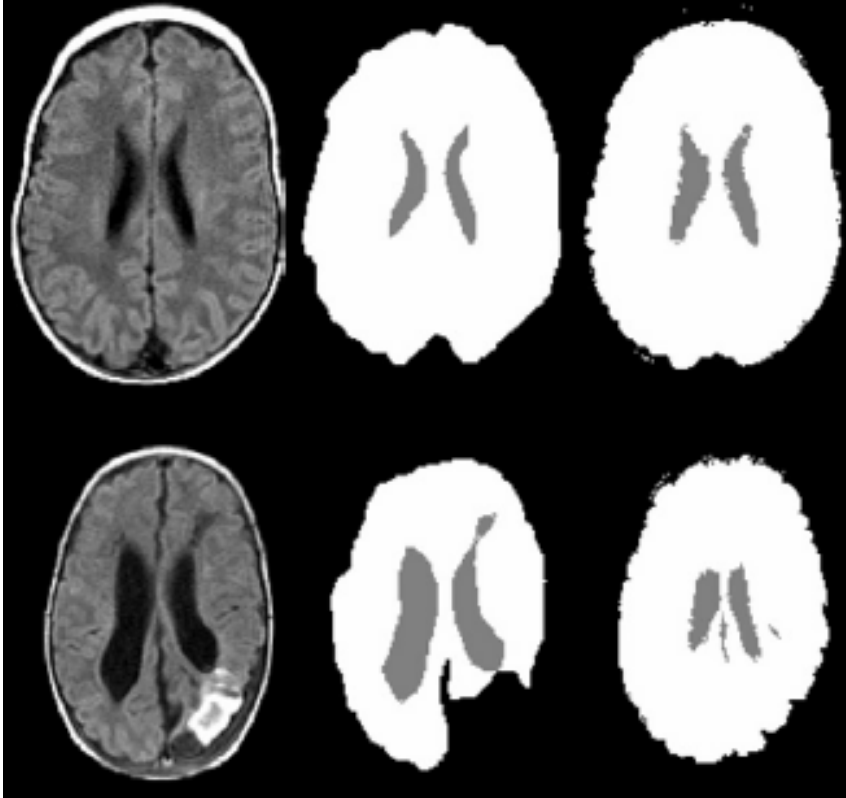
Segmentation of the CSF and GM+WM regions of MR images from premature infants without and with anomaly.<sup>2</sup>
